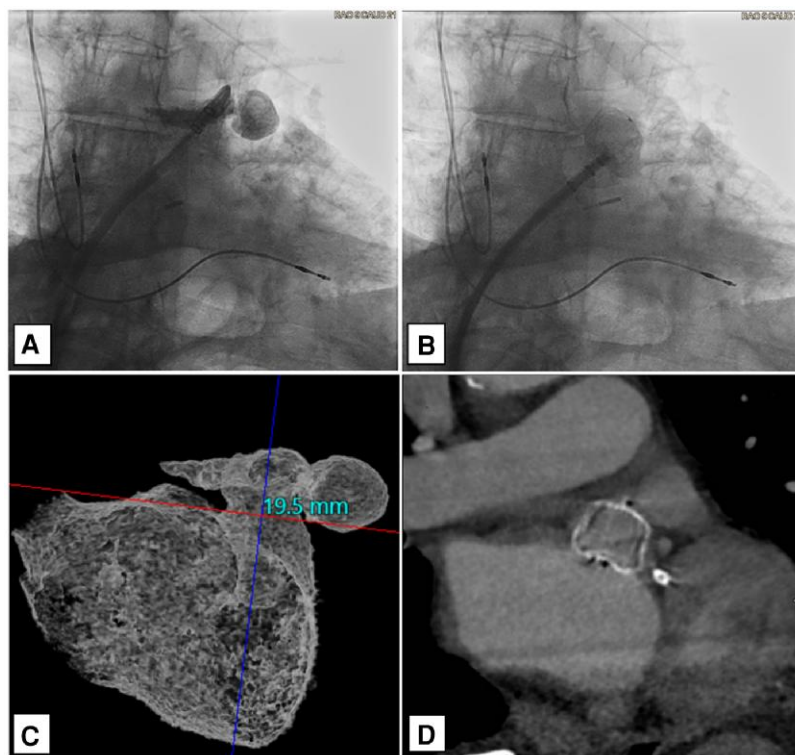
Intra-procedural view of aneurysmal segment of LAA (A); ICE-guided deployment of WATCHMAN™ FLX device (B); CT reconstruction of LAA with measurement of LAA landing zone plug length (C); cardiac CT at 6 weeks follow-up demonstrating no aneurysm (D).
